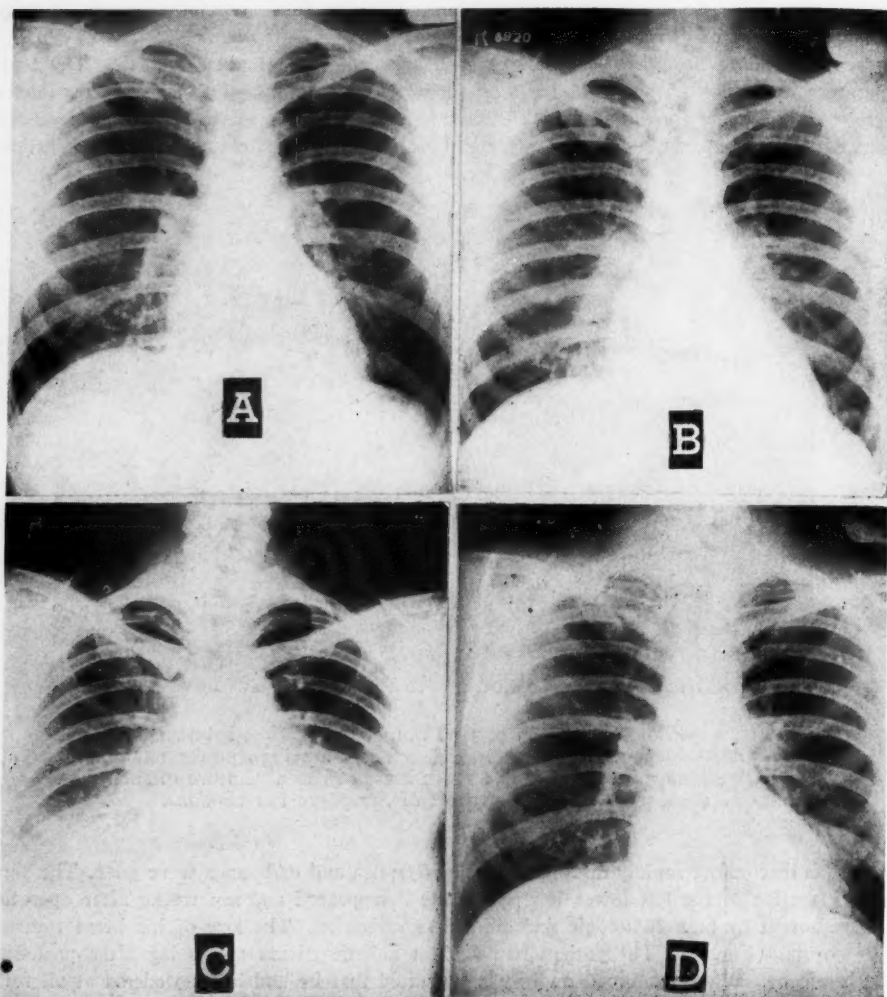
Roentgenograms showing change in heart size and the evidence of pulmonary infarction. (A) Roentgenogram taken February 13, 1945. Heart size is normal, the frontal cardiac area being 146 sq. cm. Predicted frontal area for a man of the patient's height and weight is 143 sq. cm. The method of Ungeleider and Gubner was used in computing heart size. (B) Roentgenogram taken March 1, 1945. Heart size has increased. Frontal cardiac area 168 sq. cm., 17 per cent above normal. (C) Roentgenogram taken April 23, 1945. The increased density in left lower lung field from pulmonary infarction is shown. Heart size difficult to estimate because of lung pathology and elevation of diaphragm. (D) Roentgenogram taken June 4, 1945. Postoperatively, the lung field has cleared and the heart size has returned to normal.
